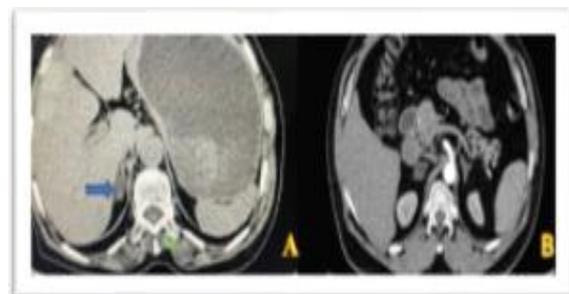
A) Non enhanced CT shows hypodense lesion (blue arrow) in the right adrenal gland. B) 50 year old
